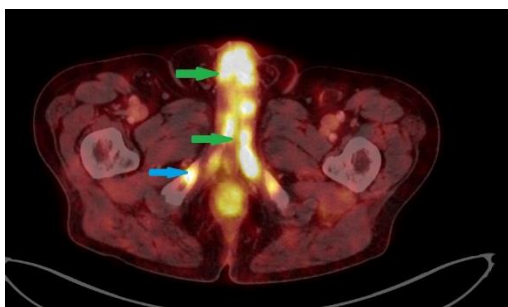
A) ⁶⁴Cu-PSMA PET/CT follow up: demonstrating a significant disease progression (green arrows), with more metastatic lesions in the Ischium dext (blue arrow), PSA 152 µg/L and B) new bone metastasis in the right scapula (yellow arrow)
